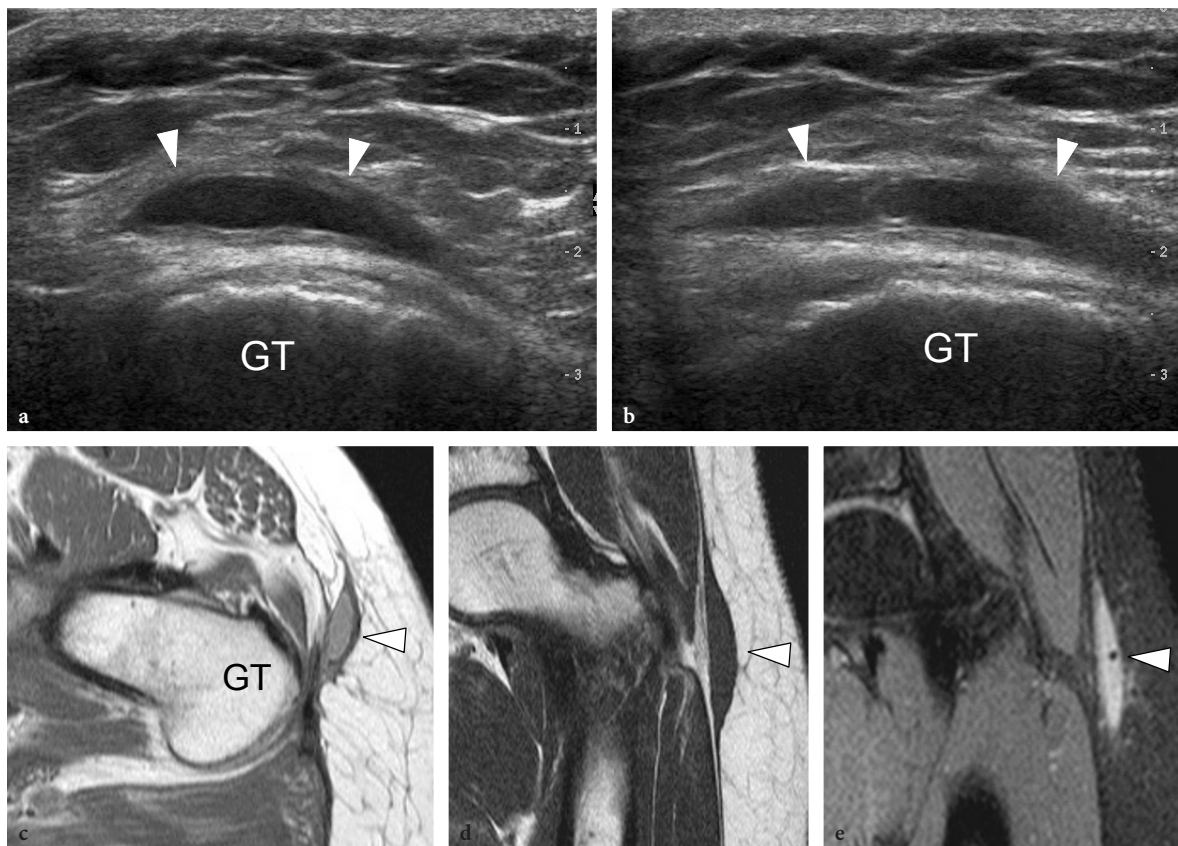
Morel-Lavallée lesion. a Transverse and b coronal 12–5 MHz US images in patient with a previous contusion trauma at the lateral aspect of the hip show a large fluid collection (*arrowheads*) with thickened walls at the level of the superficial fascia, just lateral to the fasciae latae. GT, greater trochanter. c Transverse proton density, d coronal T1-weighted and e coronal fast-STIR MR images confirm the US findings. Observe the intermediate (c), low (d) and high (e) signal intensity of the serous collection (*arrowhead*) in the different MR sequences used, which can be referred to a chronic stage of the hematoma
